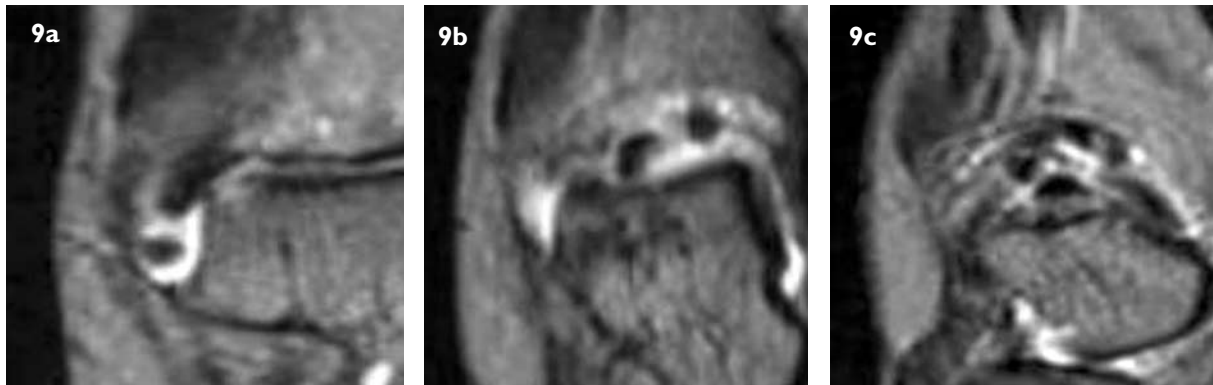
(a-c) Coronal T2-W MR images of the right ankle of a 49-year-old woman, taken from mid-joint to posterior, show a joint effusion as well as multiple hypointense round lesions at the posterior and lateral aspects of the ankle joint, consistent with synovial osteochondromatosis.
